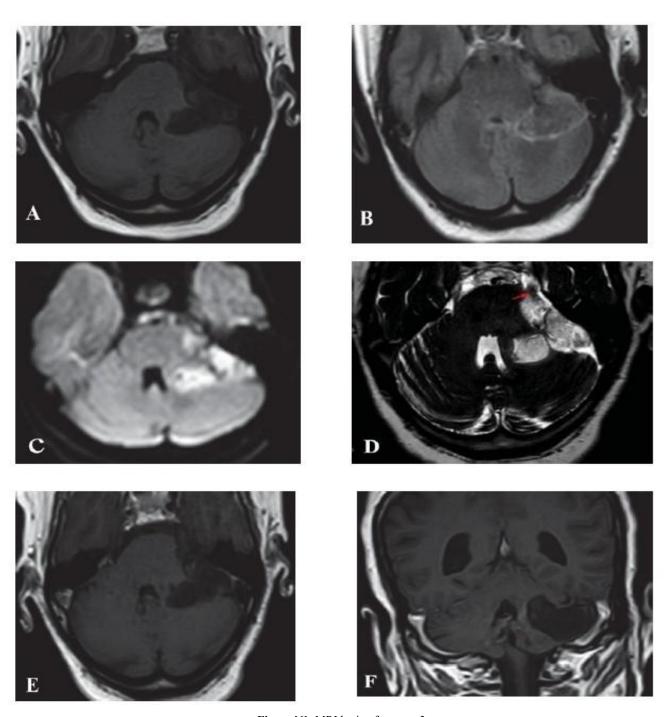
MRI brain of case no 3
